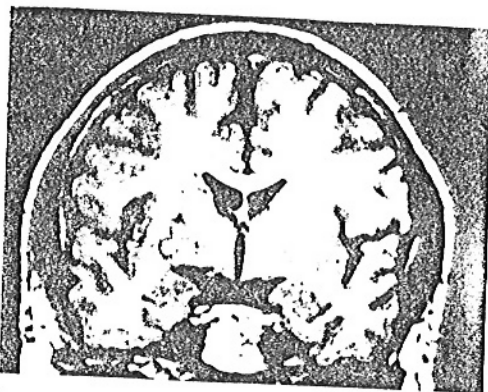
Case 4. Right-sided lesion, probably due to disulfiram intoxication, involving parts of the putamen, of the lateral pallidum segment and probably of the caudate. This MRI section (coronal plane, T1 weighted sequence) showed less marked lesions than did the CT scan, where bilateral lucencies were present in the pallidal areas. CT scan was performed, however, six months earlier than MRI.
